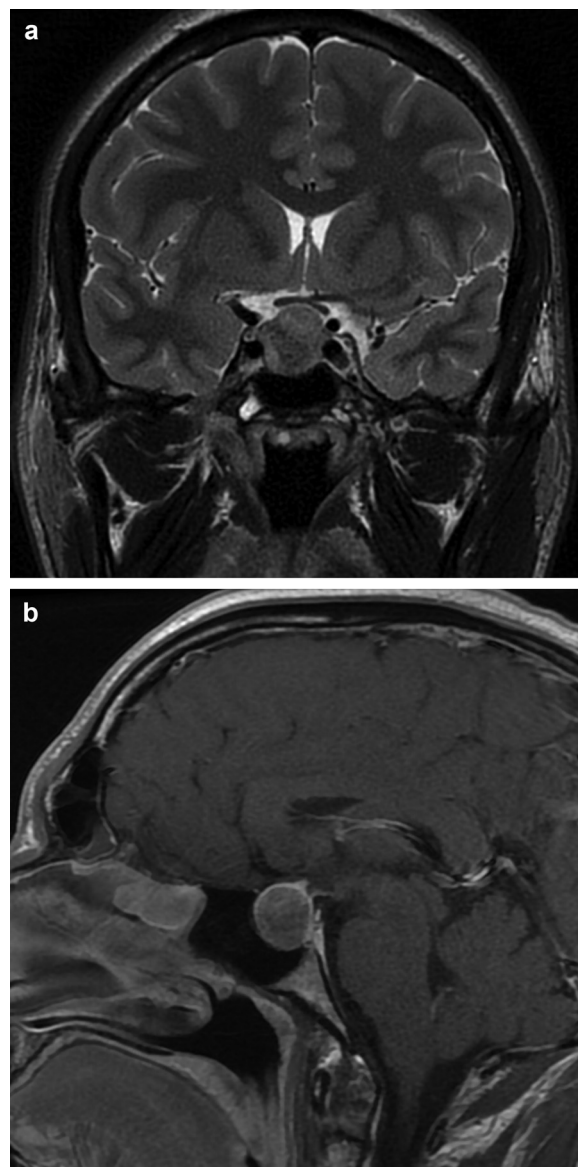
(A) Coronal T2-weighted and (B) sagittal post-contrast T1-weight imaging of the brain showed a 2 cm sellar mass with suprasellar extension, consistent with a pituitary macroadenoma.
